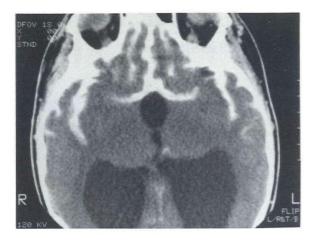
Computed tomography of brain (transverse section) at the level of the sella demonstrates ballooning of the third ventricle into the sella.
